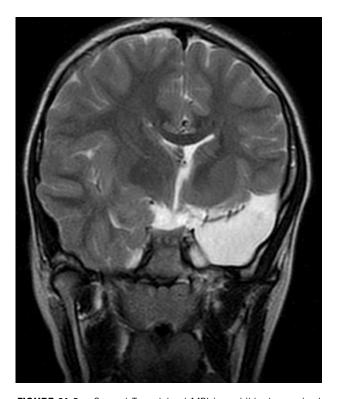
Coronal T_2 -weighted MRI in a child who survived HSV-1 encephalitis shows complete cystic encephalomalacia of the left temporal lobe and volume loss of the left hemisphere.
